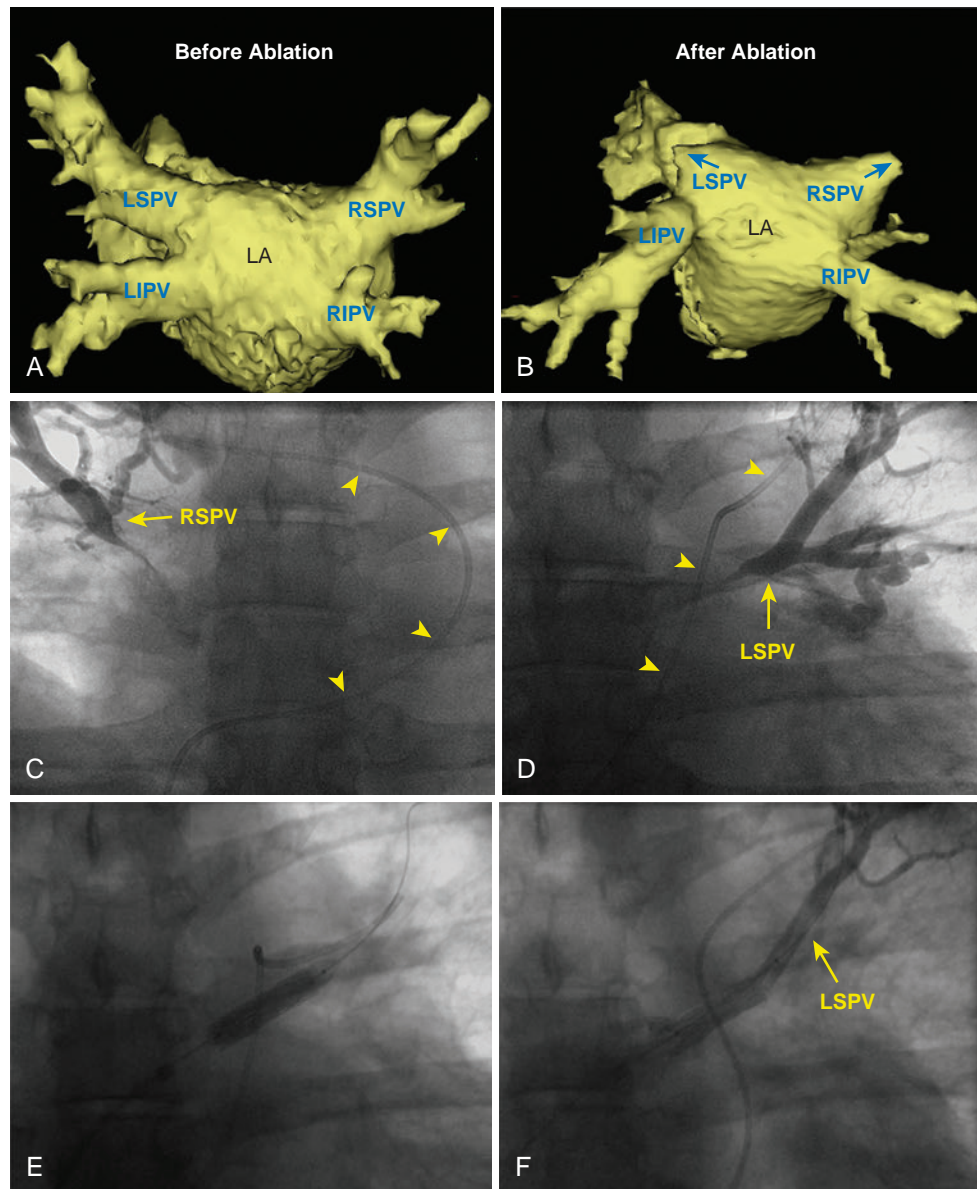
Pulmonary Vein (PV) Occlusion. *Upper panels,* Computed tomography (CT) image of the left atrium (LA) and PVs at baseline before segmental PV isolation (A) and 5 months after ablation (B). Following ablation complete occlusion of both superior PVs is observed. *Middle panels,* Fluoroscopic (antero-posterior) views during angiography of the right superior PV (RSPV) (C) and left superior PV (LSPV) (D), showing severe stenosis-occlusion of both PVs at the ostia. PV angiography was performed with contrast injection via a catheter positioned in the pulmonary artery (arrowheads). *Lower panels,* Fluoroscopic (antero-posterior) views during stenting of the LSPV: (E) Angioplasty balloon is inflated for stent deployment in the LSPV; (F) angiogram of the left superior PV following stenting. LIPV, Left inferior PV; RIPV, right inferior PV.
